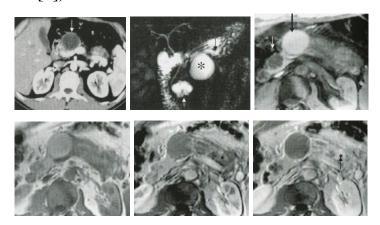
CT, MRCP, dynamic MRI in a 34-years-old patient with pancreas divisum and severe CP (by J.E. Dominguez-Munoz, 2005 [4]):
